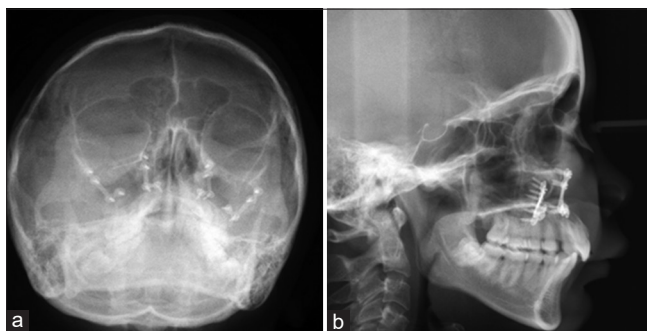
(a and b) Postoperative X-ray shows the removal of displaced maxillary third molar on the right side
